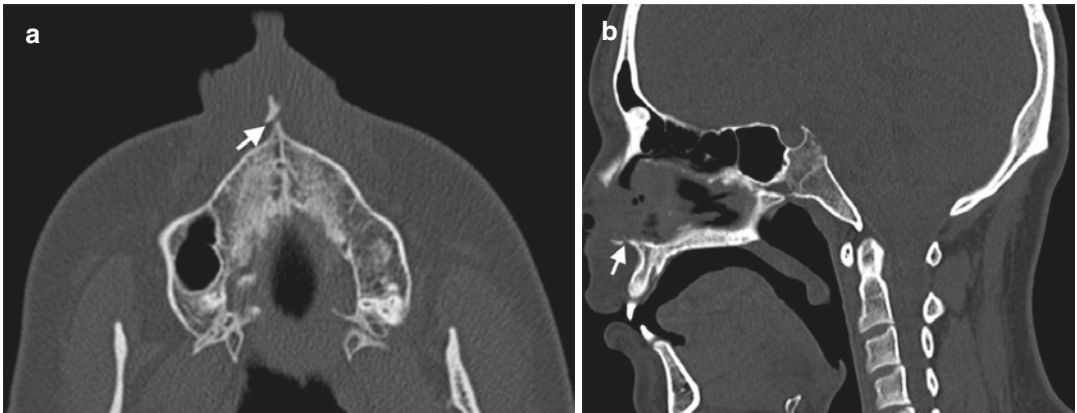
Anterior nasal spine fracture in a 21-year-old woman after MVA. Axial (a) and sagittal (b) CT images demonstrate anterior nasal spine fracture (arrows)
